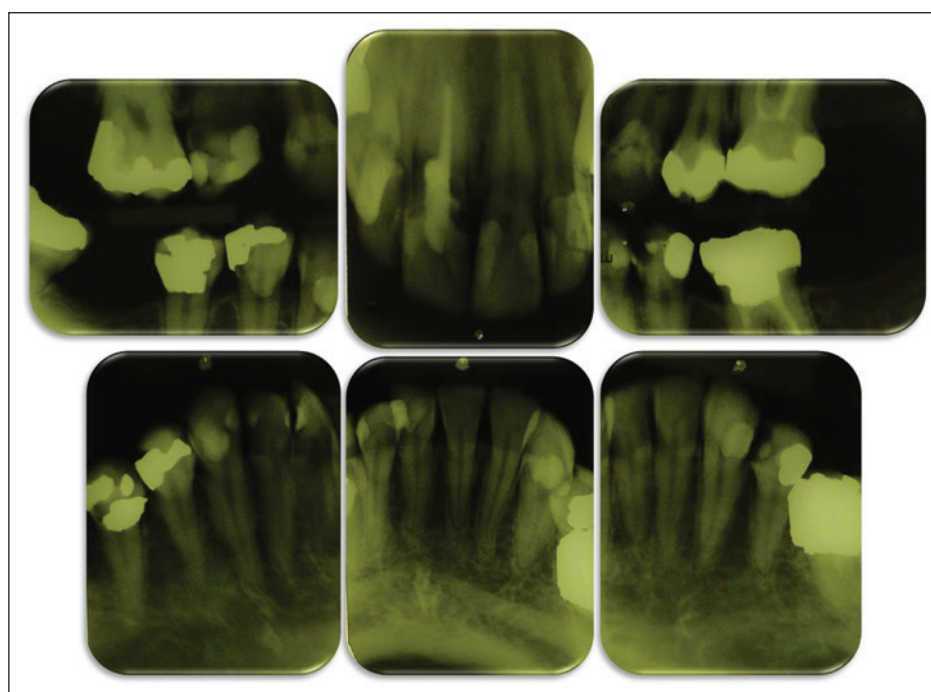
Periapical and interproximal radiographs.
